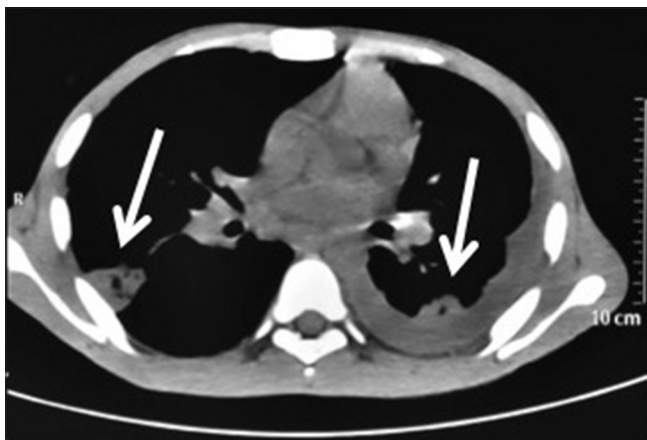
Computed tomography-chest showing bilateral pleural-based pulmonary infarcts with left-sided pleural effusion
